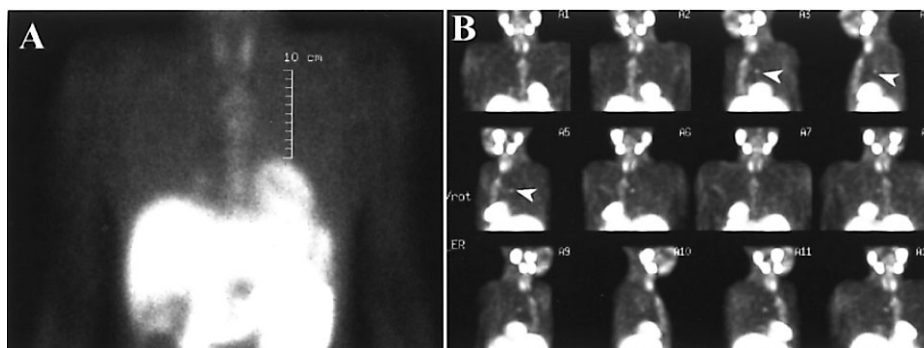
An early-phase planar image (A) and 3 dimensional MIP image (B) in the same patient of Figure 3. These images were obtained 1 month after the removal of the ectopic parathyroid in the mediastinum. The repeated scintigram 8 months later also showed the same findings.
